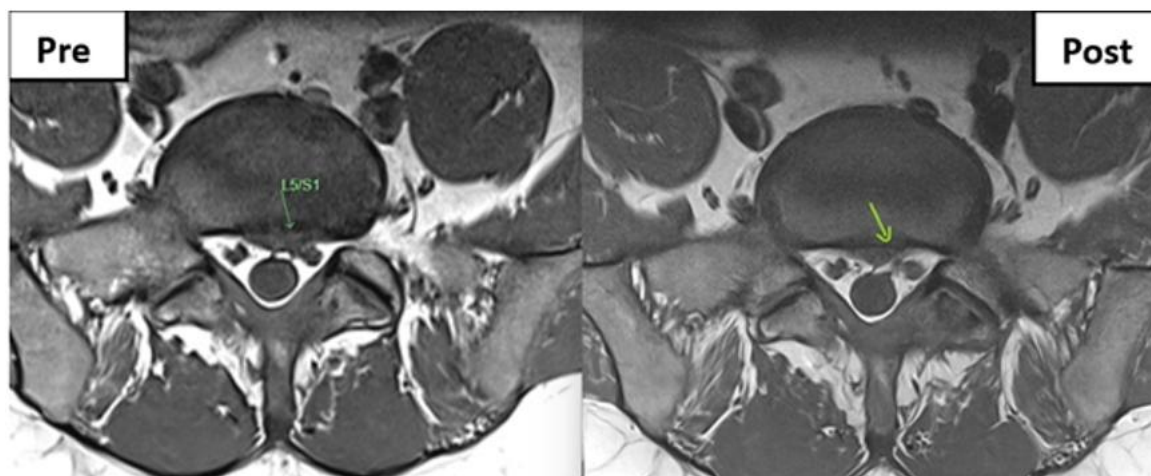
MRI T2 transverse images indicate a decrease in the L5/S1 disc protrusion and associated nerve compression.
